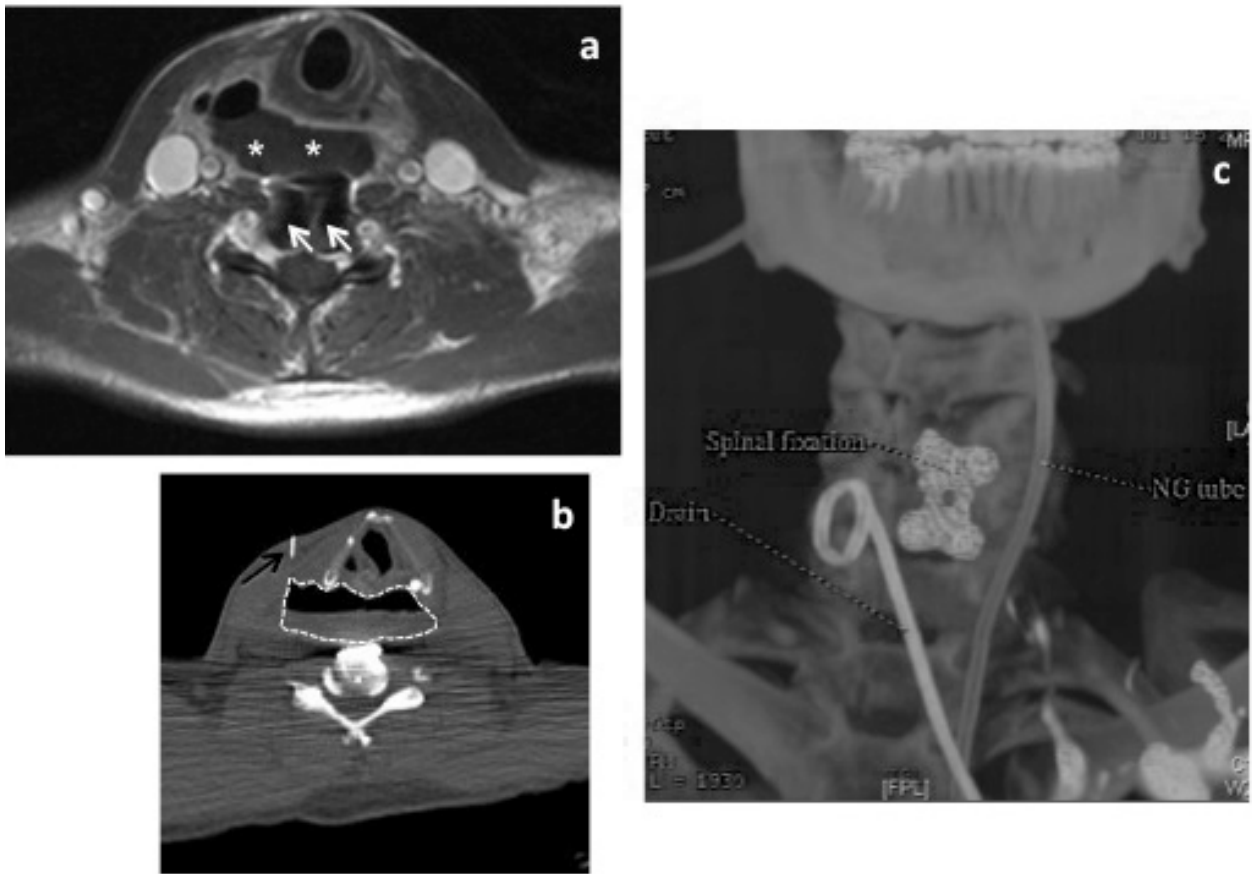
Image-guided drainage. (a) Axial T1-weighted MRI demonstrates a pre-vertebral infected collection (*white asterisks*) anterior to the level where metal instrumentation is present (*white arrows*). (b) Axial CT image shows introduction of needle (*black arrow*) from a right anterior approach into the infected, gas-containing collection (*dashed outline*). A drain was then inserted into the collection using a Seldinger technique. (c) Coronal maximum intensity projection (MIP) CT image demonstrates the drain in situ.
